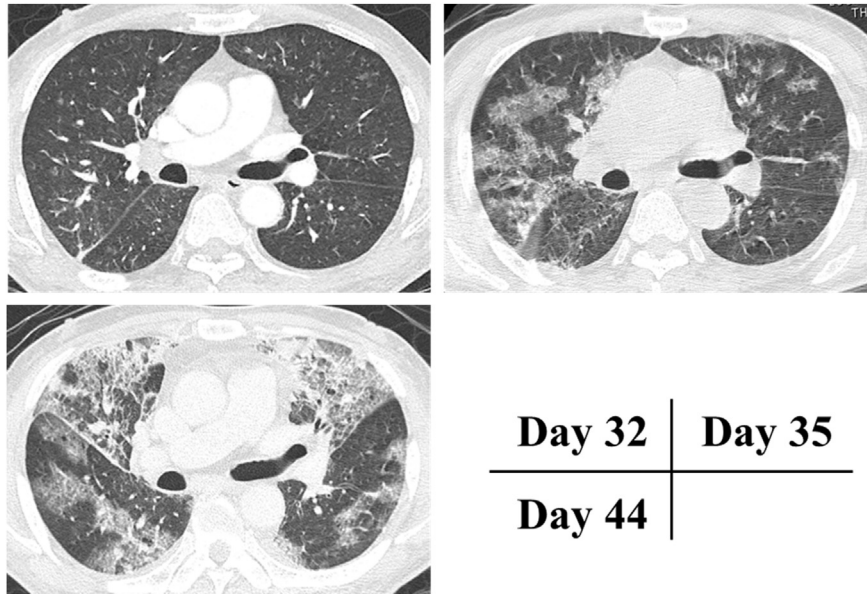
Representative images of chest CT. Small centrilobular nodules suggesting bronchiolitis were observed on day 32. Multiple patchy ground-glass opacities were appeared in bilateral lungs on day 35, and these shadows were worsened on day 44.
